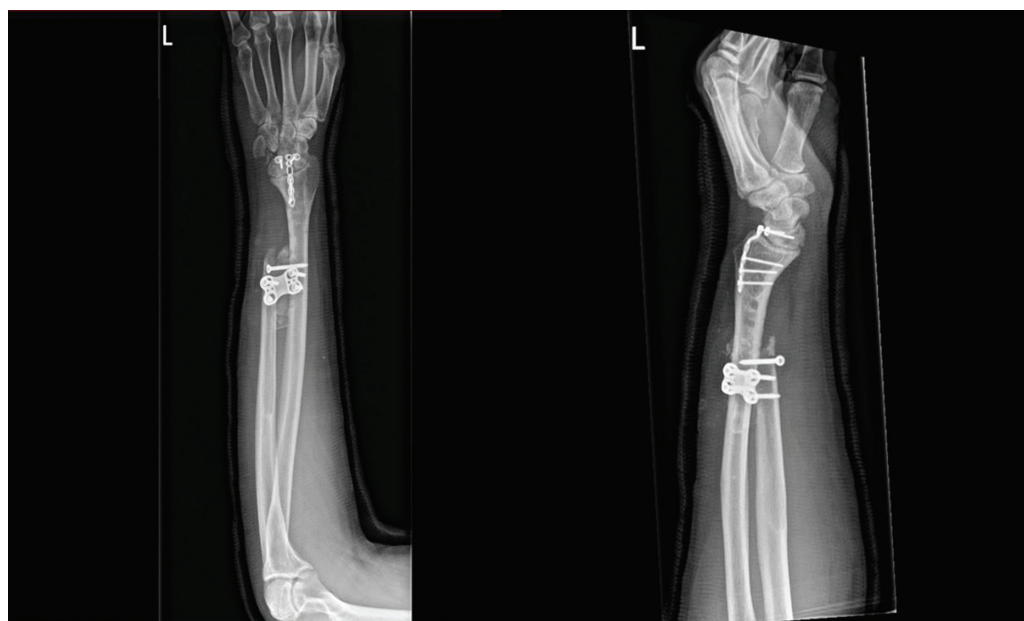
Anteroposterior and lateral X-rays of Case 3, 1 week after one bone forearm procedure.
